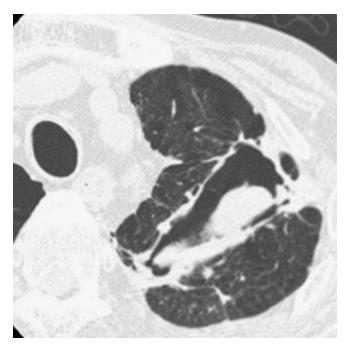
Chronic necrotizing aspergillosis. Chronic necrotizing aspergillosis in a 62-year-old man who had received steroid treatment. High-resolution computed tomography, showing a large cavity lesion that contained a fungus ball in the left upper lobe. *Aspergillus fumigatus* was identified from sputum.
